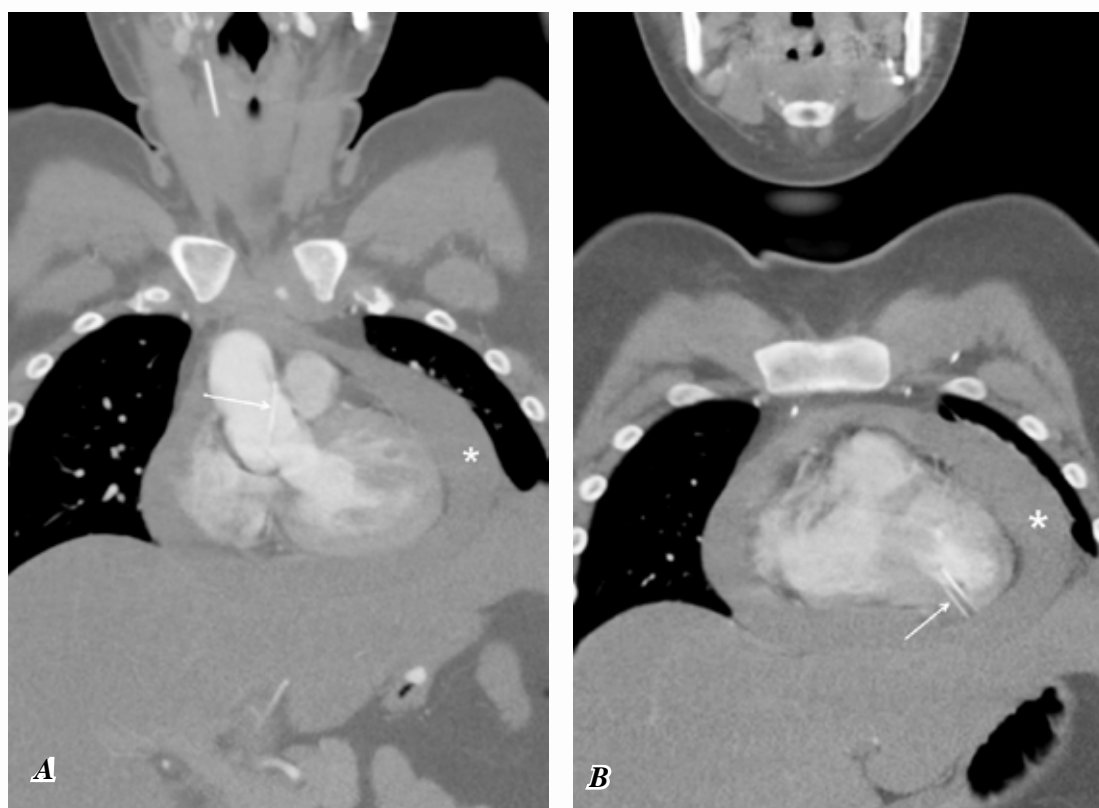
Coronal sections of computed tomography of the thorax showed a needle in the aortic root (A) and in the left ventricle/left ventricular myocardium (B) (white arrow) and hemopericardium (white star)
